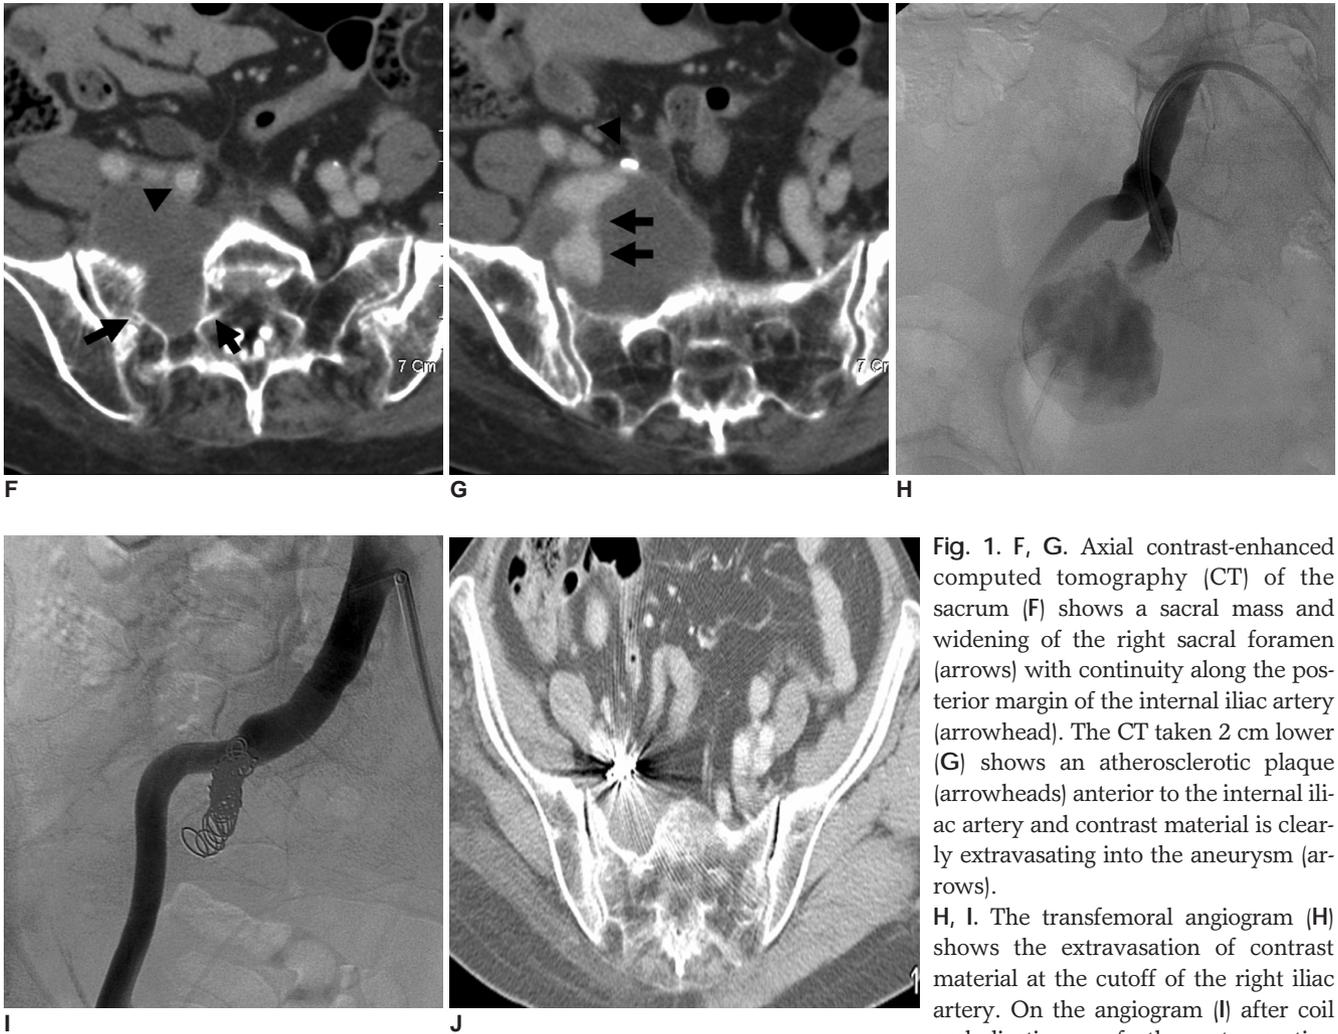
F, G. Axial contrast-enhanced computed tomography (CT) of the sacrum (F) shows a sacral mass and widening of the right sacral foramen (arrows) with continuity along the posterior margin of the internal iliac artery (arrowhead). The CT taken 2 cm lower (G) shows an atherosclerotic plaque (arrowheads) anterior to the internal iliac artery and contrast material is clearly extravasating into the aneurysm (arrows). H, I. The transfemoral angiogram (H) shows the extravasation of contrast material at the cutoff of the right iliac artery. On the angiogram (I) after coil embolization, no further extravasation
